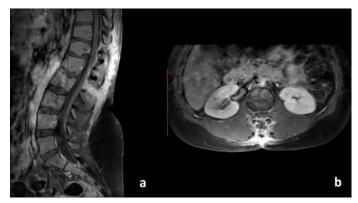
L1-L2 epidermoid lesion total excised. Postoperative 4thmonth thoracolumbar T1 contrast sagittal (a) and axial (b) section MRI
